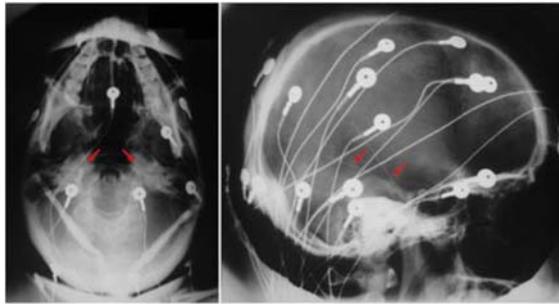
Basal and lateral X-rays showing scalp and intracranial FO electrodes (pointed to by red arrows).
